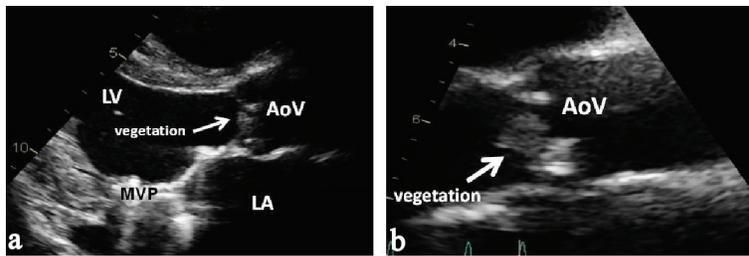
Transthoracic echocardiogram showing normal mitral valve prosthesis (MVP) (a), and large vegetation on the aortic valve (AoV) (b).
